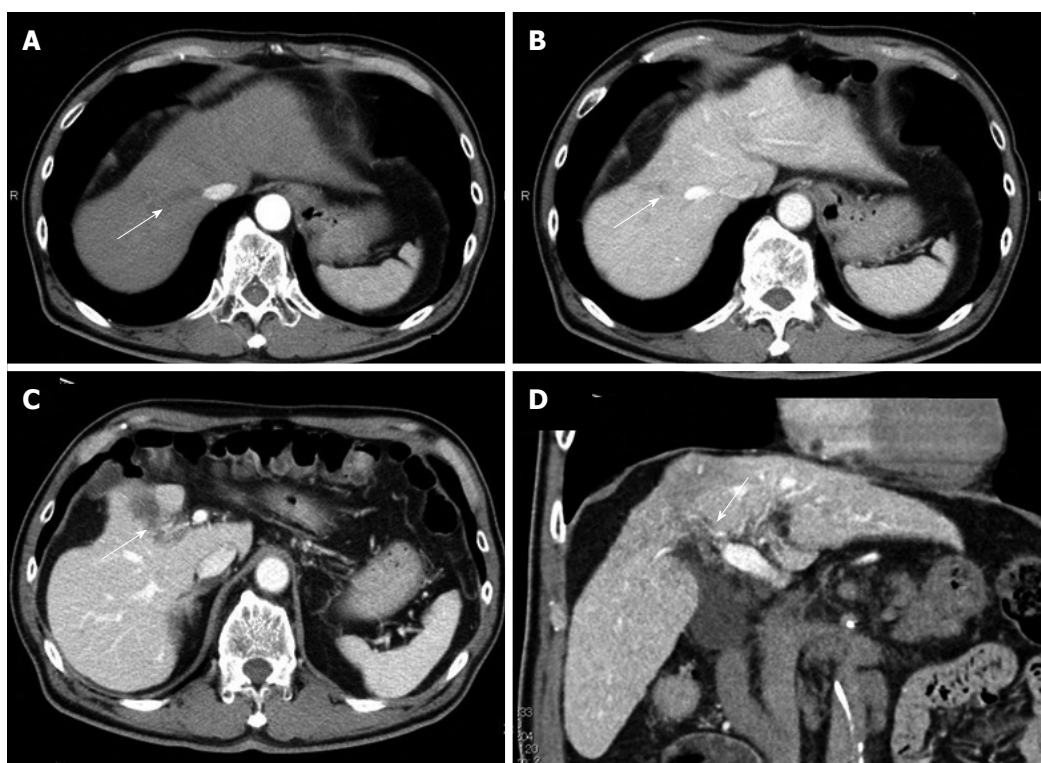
Fourteen months after sorafenib induction. Computed tomography revealed the tumor disappearance (A and B, arrow) and the residual portal vein tumor thrombosis (C and D, arrow) in the right anterior portal vein.
